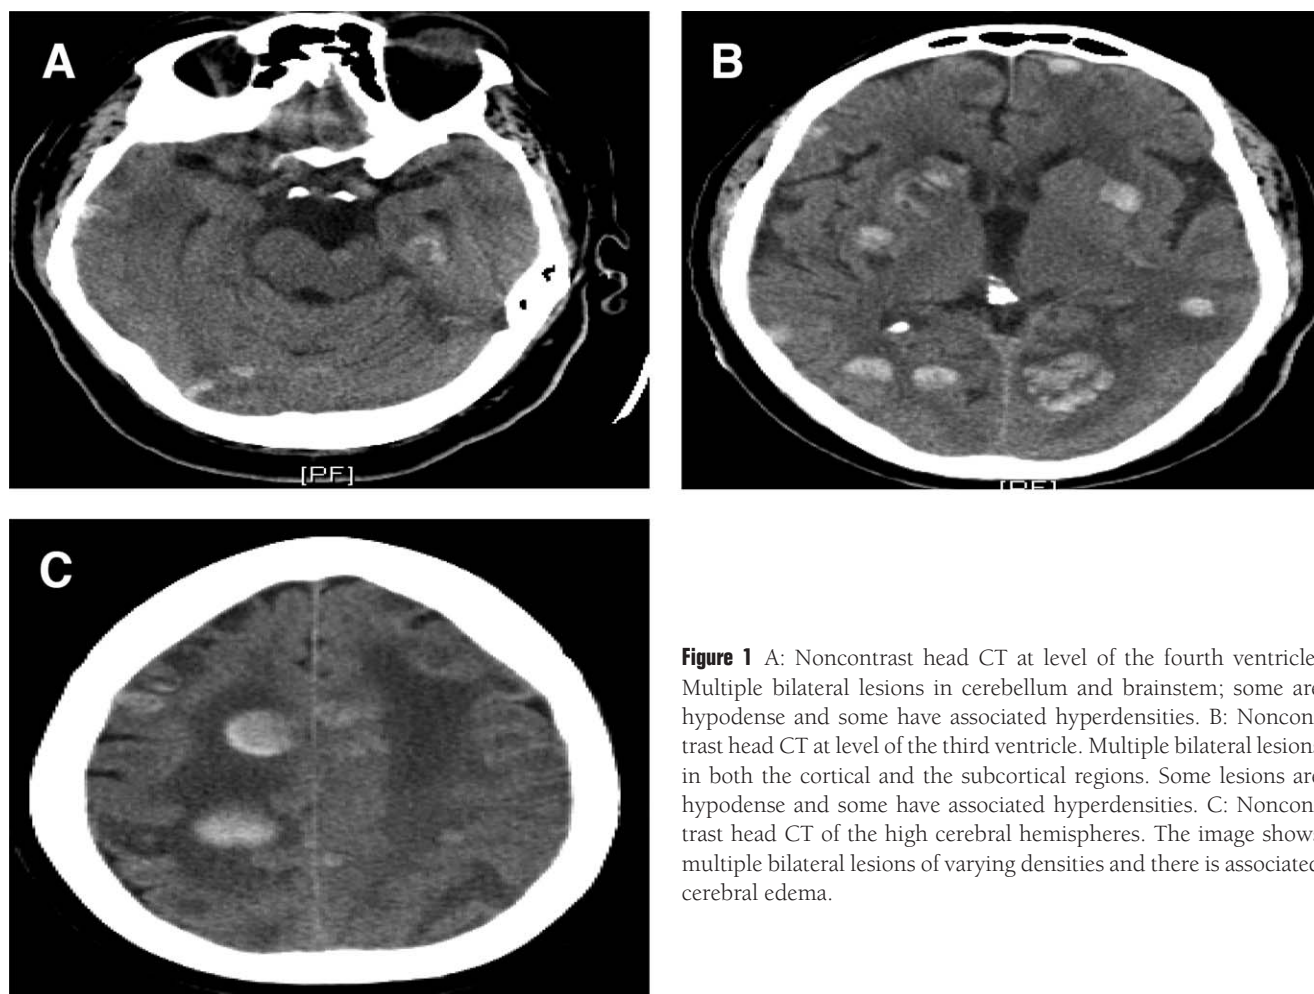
A: Noncontrast head CT at level of the fourth ventricle. Multiple bilateral lesions in cerebellum and brainstem; some are hypodense and some have associated hyperdensities. B: Noncontrast head CT at level of the third ventricle. Multiple bilateral lesions in both the cortical and the subcortical regions. Some lesions are hypodense and some have associated hyperdensities. C: Noncontrast head CT of the high cerebral hemispheres. The image shows multiple bilateral lesions of varying densities and there is associated cerebral edema.
